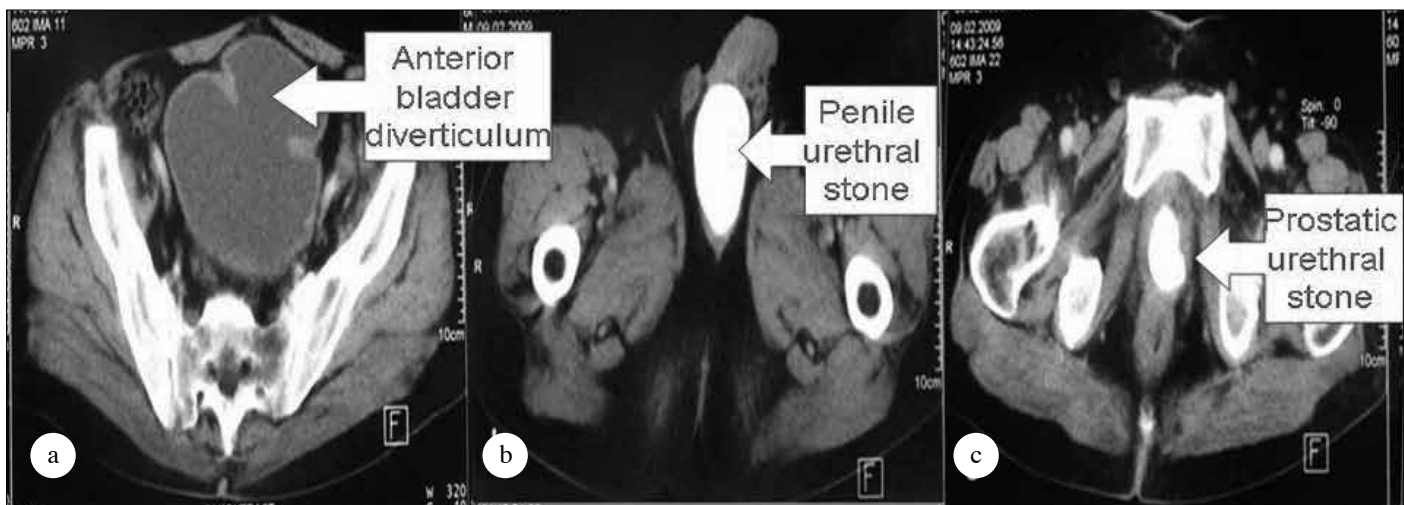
Abdominal CT slices of the patient with an anterior bladder diverticulum (a), calcification lodged in the prostatic urethra (b) and penile urethra (c)
